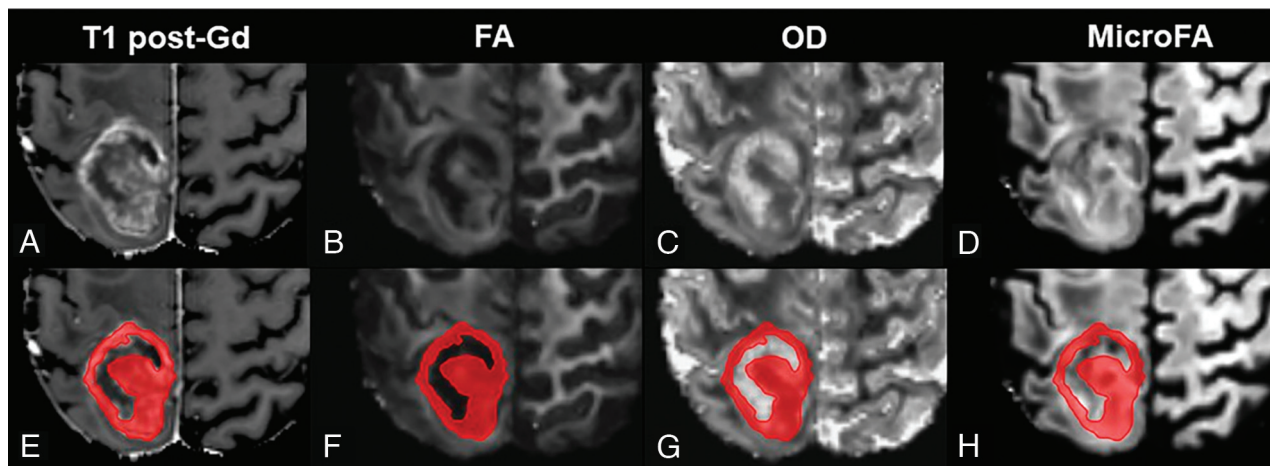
Presurgical (3T) MR imaging in a patient with a right parietal GBM. Representative axial images are shown in the *upper row* (A–D) with the corresponding ROI (of contrast-enhancing tumor components based on A) overlaid sections in the *lower row* (E–H). Gd indicates Gadoteridol.
